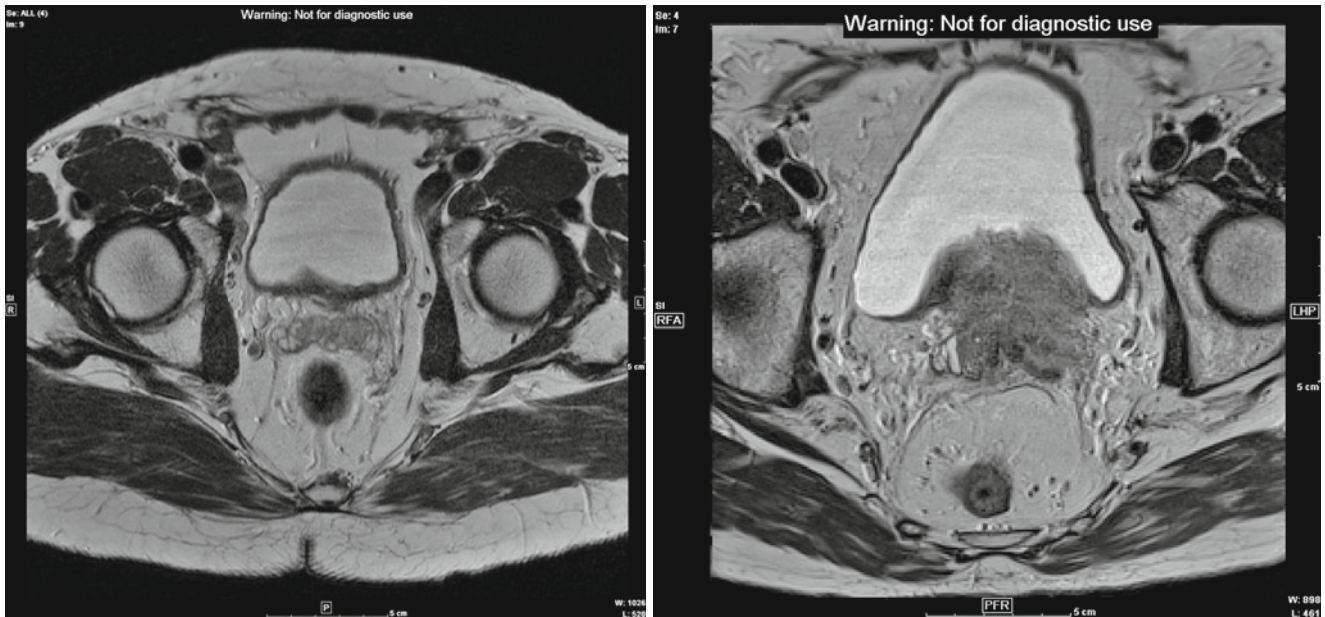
T2 MRI demonstrates invasion of the seminal vesicles in keeping with T3B carcinoma of the prostate in both images
